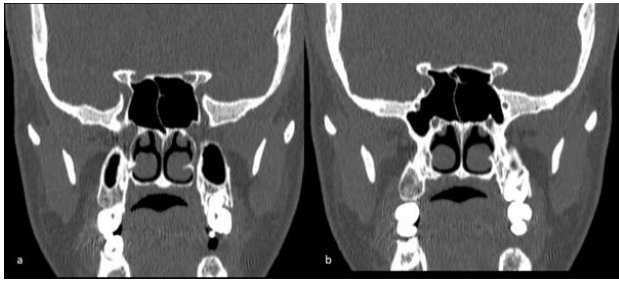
Coronal parasasal CT image of a 30-year-old woman with ACPP. a, Coronal CT section showing DELANO TYPE 2 Optic nerve canal (thick arrow). b, Coronal CT section showing ACPP (thin arrow).
